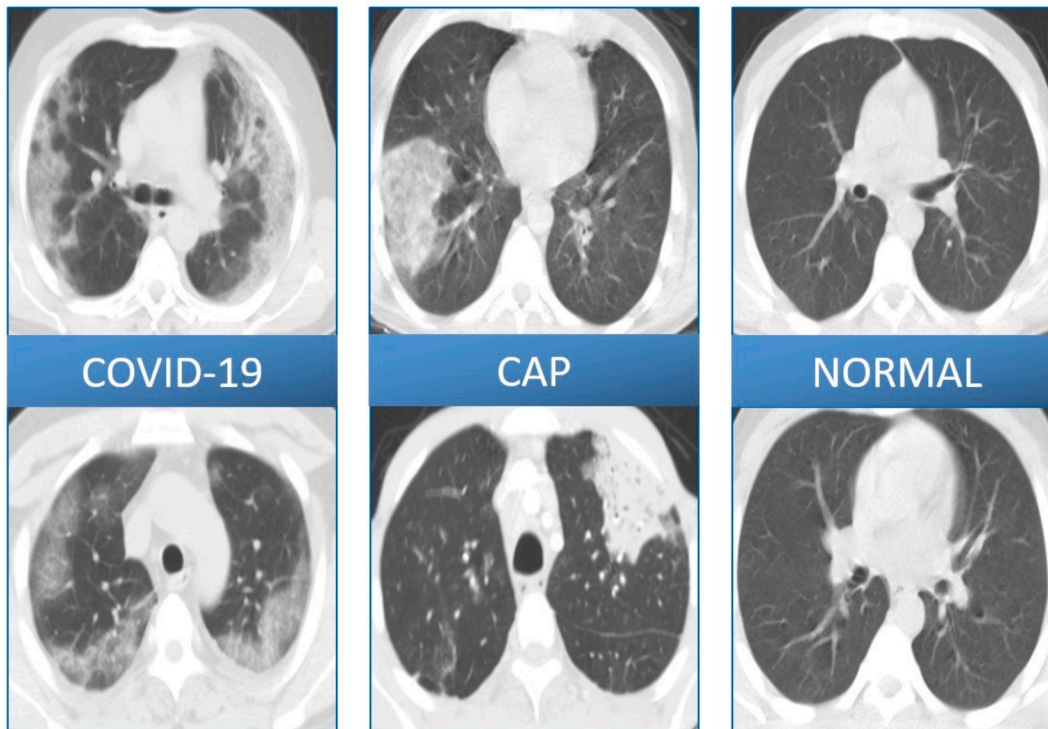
Representative images from CT-MTU dataset.
